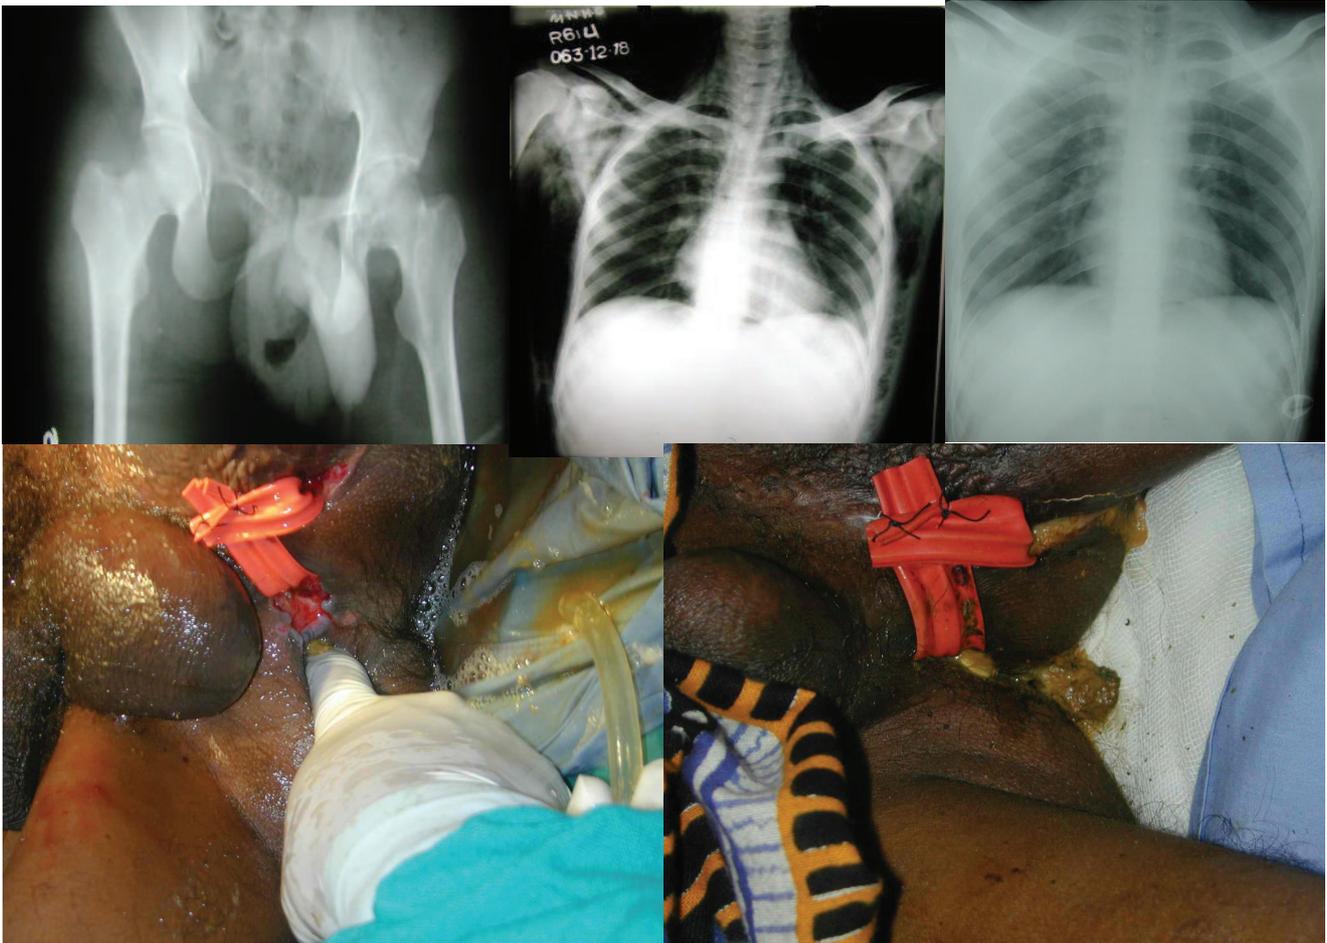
Figure A-E. A- Fracture of the Pelvis; B- Initial Normal X-Ray; C- X-Ray with Surgical Emphysema; D- Punctured wound in the perineum. E- Fecal material from perineal wound.
